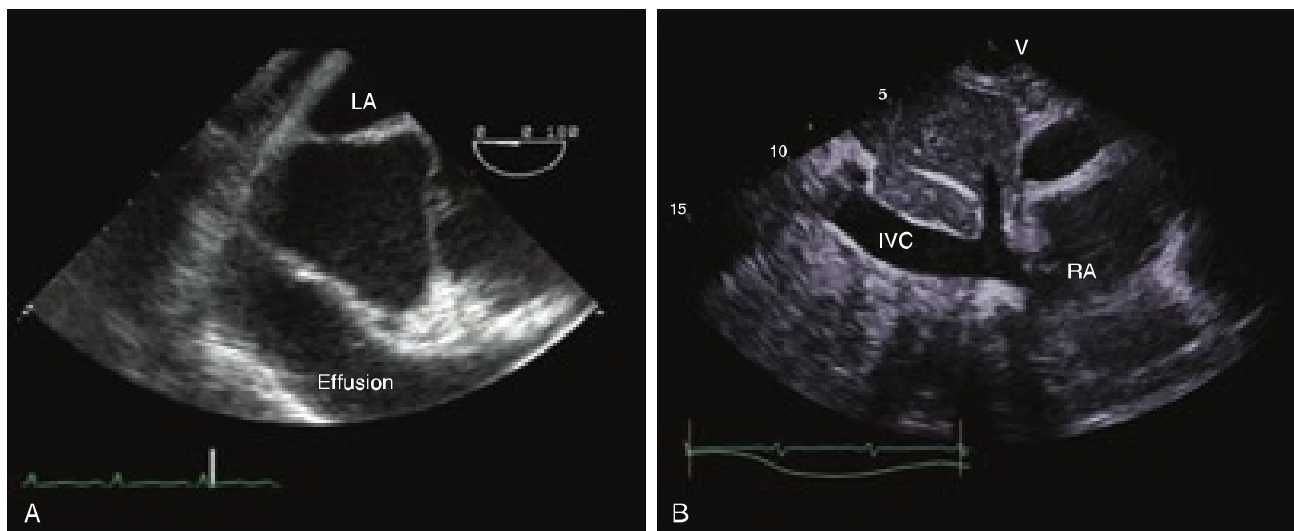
(A) Transesophageal echocardiography, midesophageal four-chamber view with focus on the right atrium. Collapse of the right atrium during ventricular systole can be visualized. (B) Subcostal inferior vena cava view on transthoracic echocardiography on a patient with cardiac tamponade. A dilated, plethoric inferior vena cava is seen. IVC, Inferior vena cava; LA, left atrium; RA, right atrium.
